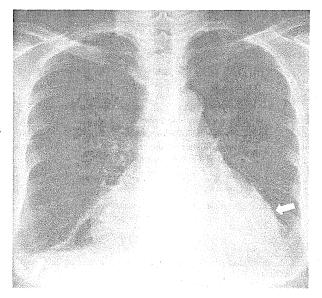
Chest X-ray obtained upon admission shows cardiac enlargement (60%), increased pulmonary markings and bilateral pleural effusion.
